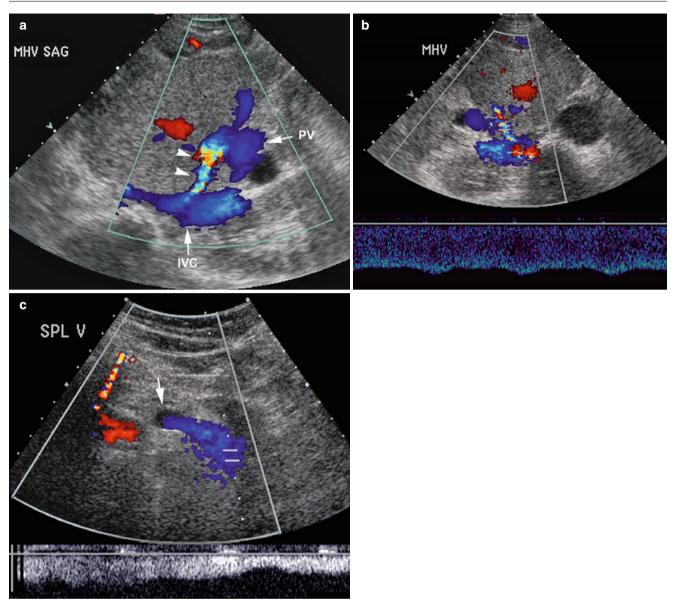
Portosystemic shunts. (a) Color Doppler sagittal sonogram of the liver demonstrating a vessel with high flow (*arrowheads*) carrying blood from the portal vein (*arrow*, *PV*) to the inferior vena cava (*arrow*, *IVC*), representing a shunt from the portal vein to the middle hepatic vein. (b) Color and spectral Doppler of the portal-hepatic shunt
